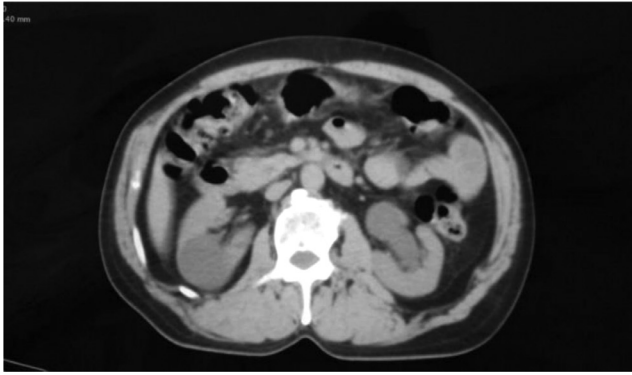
Axial plain CT images of the abdomen showing left hydronephrosis and proximal hydroureter.
